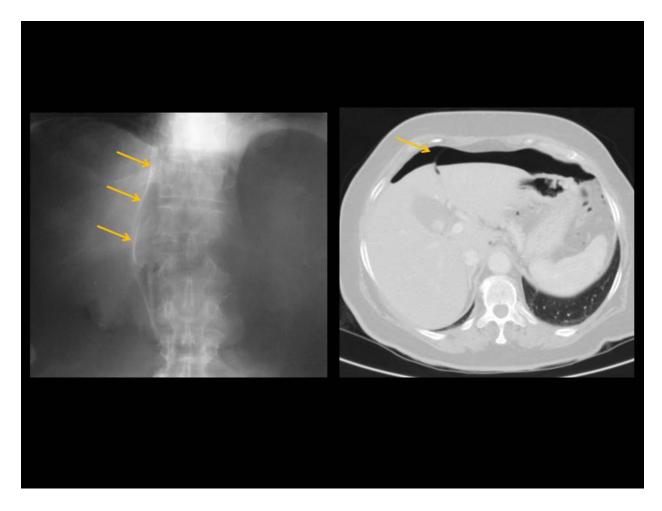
Falciform ligament sign. In the supine position, the gas assumes an anterior placement best appreciated by the falciform ligament sign, which consists of free air outlining the falciform ligament, demonstrated on the plain radiographs and on CT scan.
